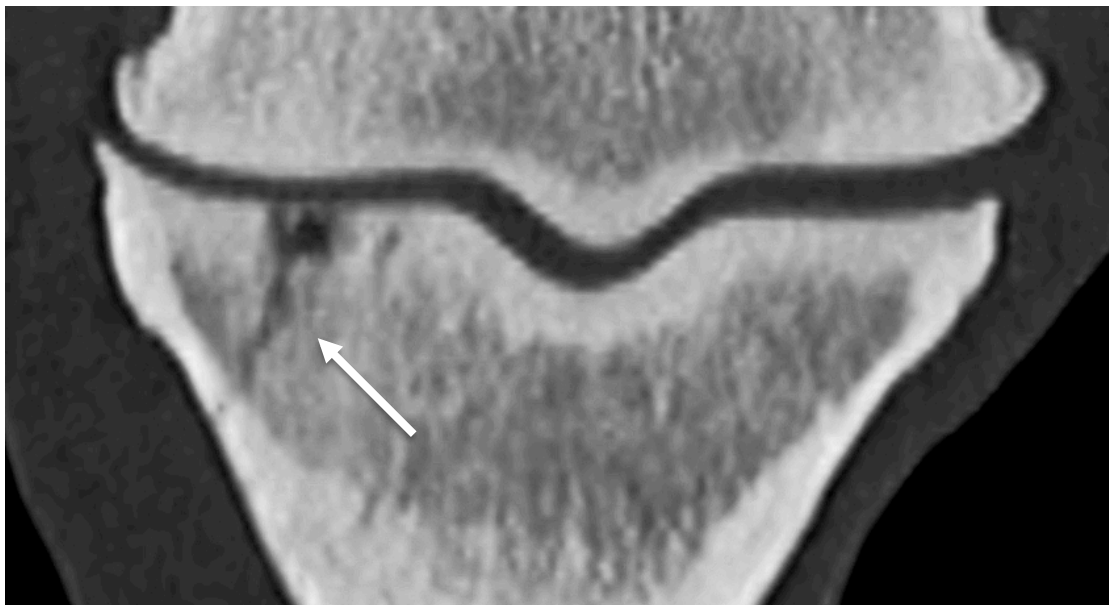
Dorsal CT view of the same SCL showing a channel (arrow) between the cyst and the medial cortex of P1. Scrolling through the CT images revealed multiple channels. The cyst has an irregular margin and a heterogeneous content and communicates with the joint space. There is no fissure.
